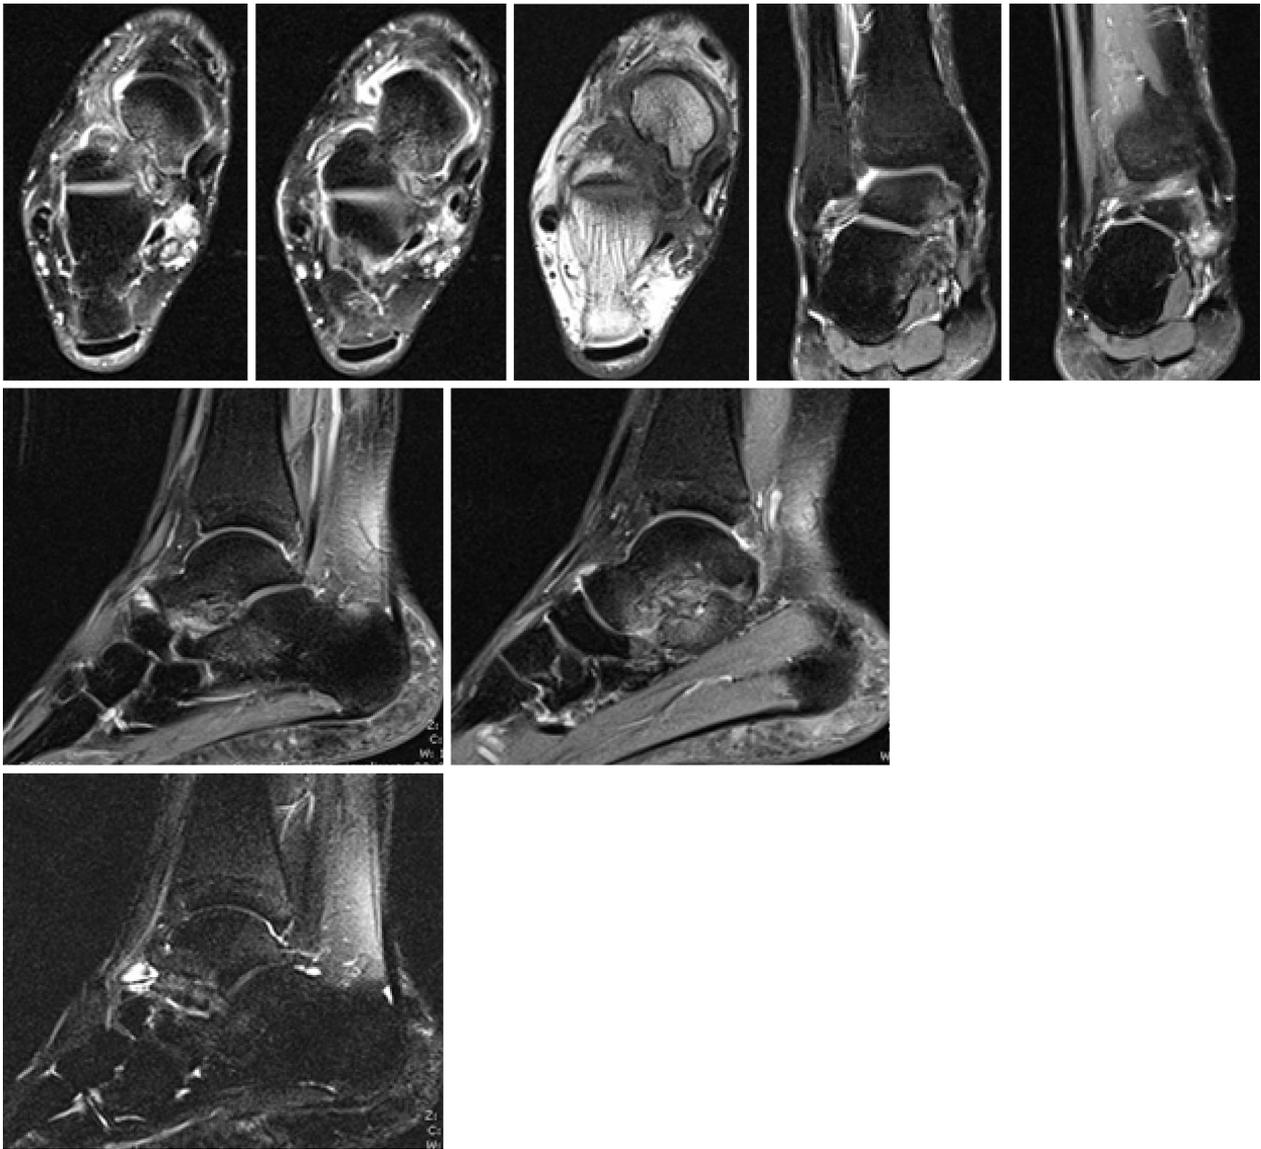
Magnetic resonance imaging of the ankle of Patient 2. Loose bodies and degenerative arthritis are shown.
